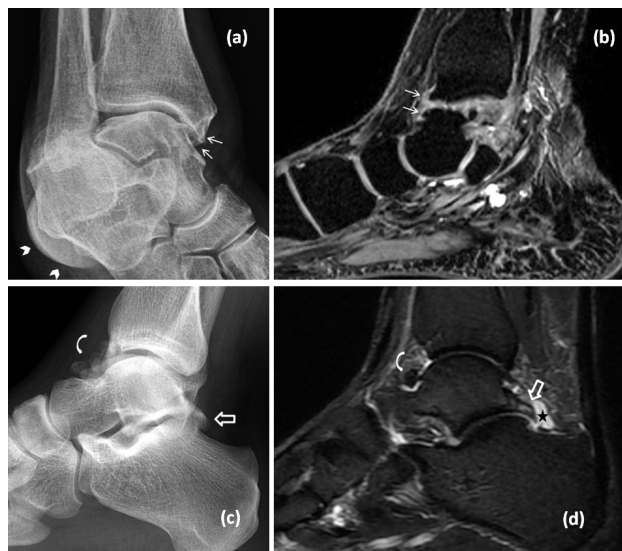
Mortise radiograph (a) and sagittal 3-D T2-weighted dual echo steady state water excitation MR image (b) of the right ankle of a 55-year-old female patient demonstrate anteromedial osteophytes at the opposing surfaces of tibia and talus (arrows). This patient was referred for a lateral sided soft tissue swelling (arrowheads in a) which turned out to be a ganglion cyst (not shown here). Anteromedial osteophytes at this location can also be seen in anteromedial ankle impingement syndrome, which is particularly common in kicking athletes. In another patient lateral radiograph (c) and short tau inversion recovery (STIR) image (d) of the ankle are shown. This 43-year-old male patient complains of crepitation and pain mostly at the posterior aspect of the ankle during running and playing football, compatible with posterior ankle impingement syndrome. The prominent Stieda process (open arrows) demonstrates bone marrow oedema on STIR image. Note that there is also effusion of the posterior subtalar recess (star) and soft tissue oedema around it. Multiple loose bodies in the anterior tibiotalar recess are also noted (curved arrows).
